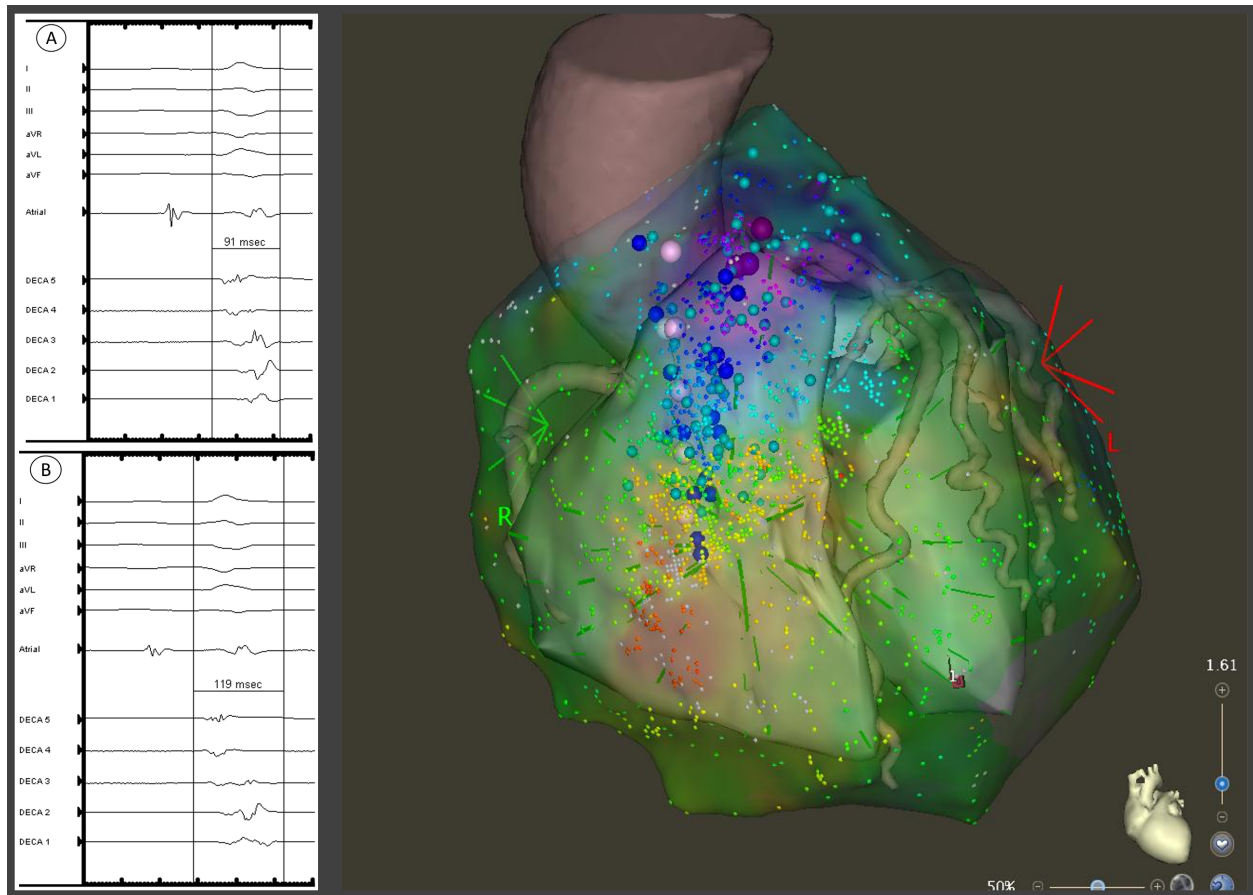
Integration of epicardial activation map with CARTOSOUND image and 3D CT scan with RVOT electrograms before (A) and after (B) pericardial warm saline infusion. The electrogram became more delayed and fractionated after warm saline infusion. The duration of the electrogram was measured from the beginning of the QRS complex.
